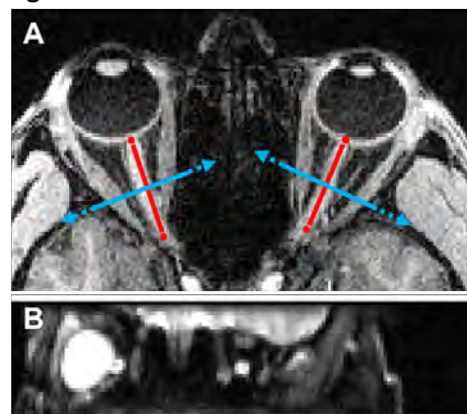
Axial structural MRI localizer for dMRI slice positioning (A) and single slice optic nerve dMRI b0 image from one of the eyes (B). Red lines (A) indicate the optic nerves and blue lines (A) indicate the dMRI slice location.
